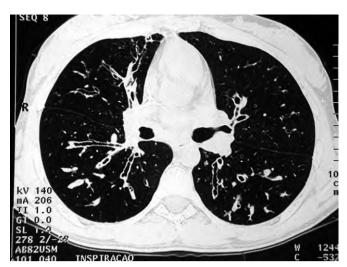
HRCT scan of a 14-year-old cystic fibrosis patient showing cylindrical bronchiectasis in lower lobes.
